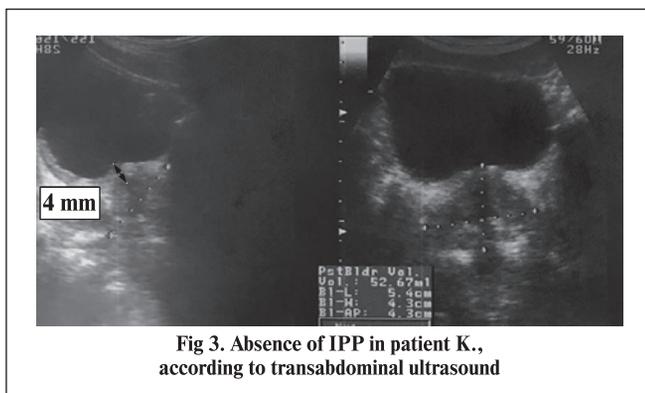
Absence of IPP in patient K., according to transabdominal ultrasound
